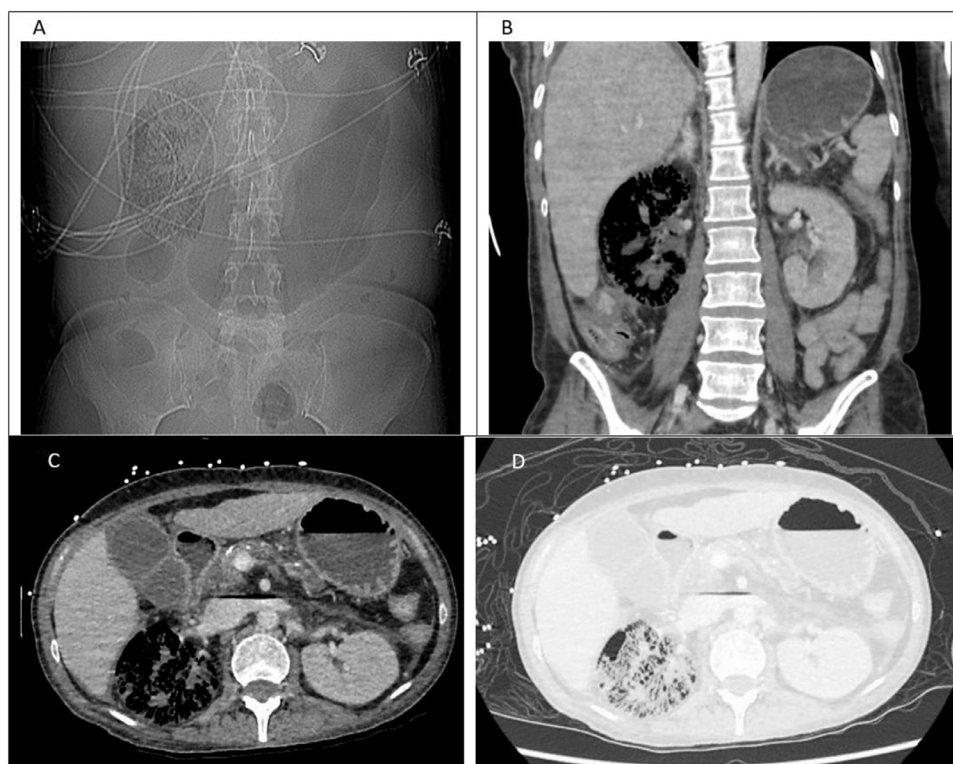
(A) PA prescan Xray showing mottled emphysematous change to the right kidney. (B) supine coronal CT showing almost complete gaseous replacement of the right renal parenchyma. (C) supine axial CT showing almost complete gaseous replacement of the right renal parenchyma, with air-fluid level in the left renal vein to the inferior vena cava. (D) same slice in C, with mottling and streaking emphysematous changes highlighted in lung window.
